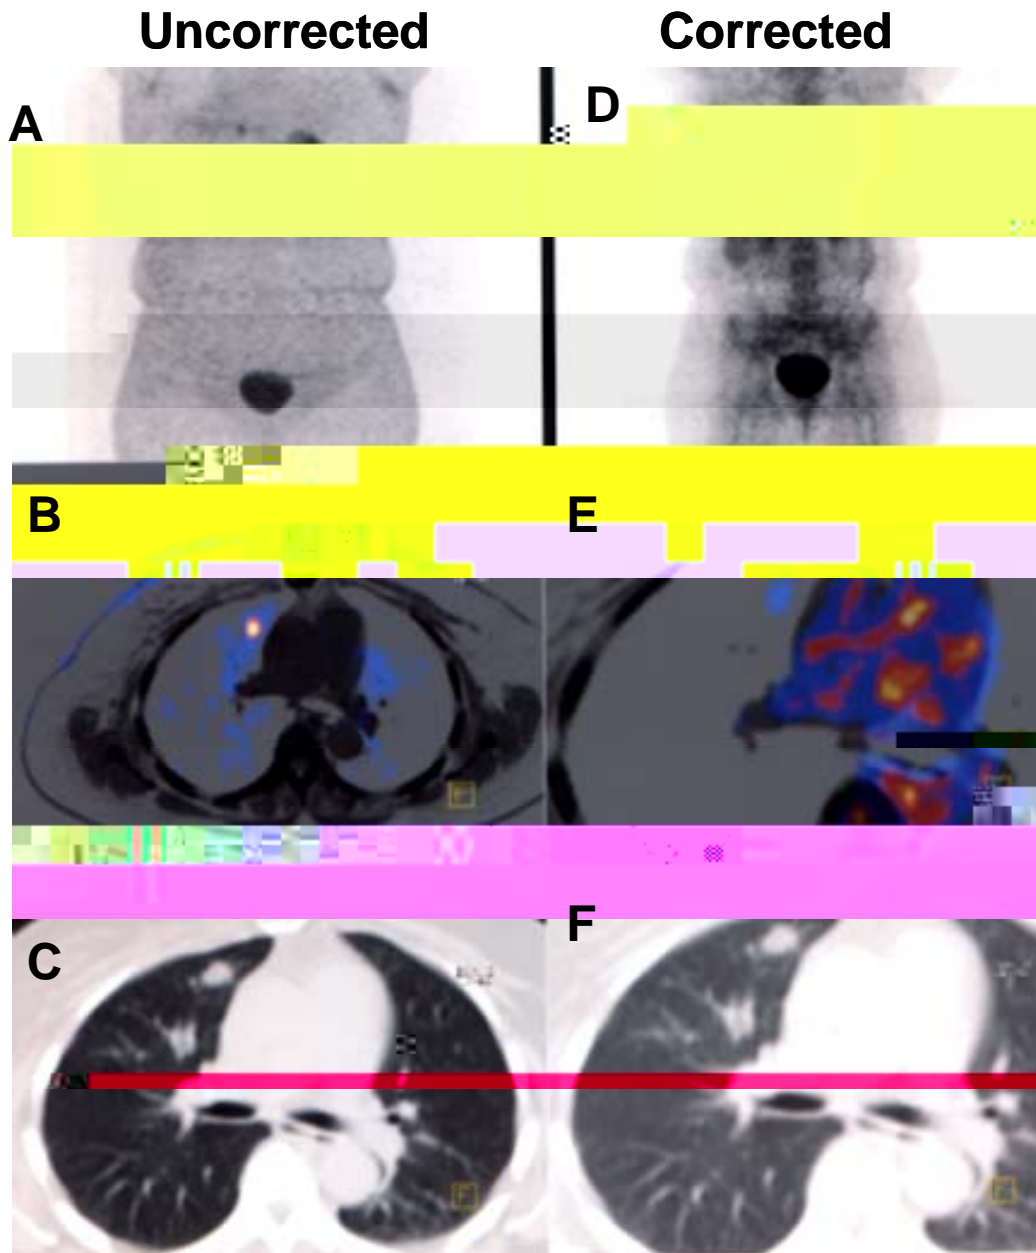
An example of the importance in optimizing display windows of both attenuation-corrected and uncorrected image sets to visualize a lesion. A-C: attenuation uncorrected image, D-F: attenuation corrected image. A lesion is visible on A, but not on D. B and E are transaxial fused PET/CT images. The lesion is easily detected on B. Only optimal windowing will allow physicians to visualize the lesion on E. C and F are transaxial CT images. The lesion is not easy to evaluate from CT images only (Courtesy of Steven Bujenovic, M.D.).
